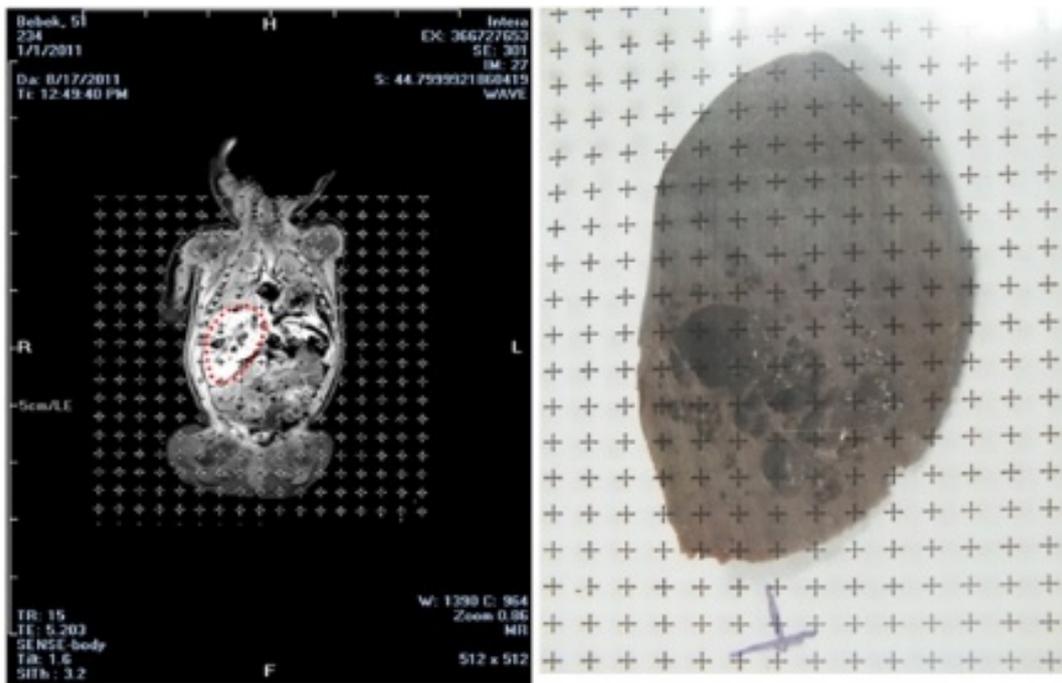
Placement of the transparent square grid test system on sliced section and on MRI
